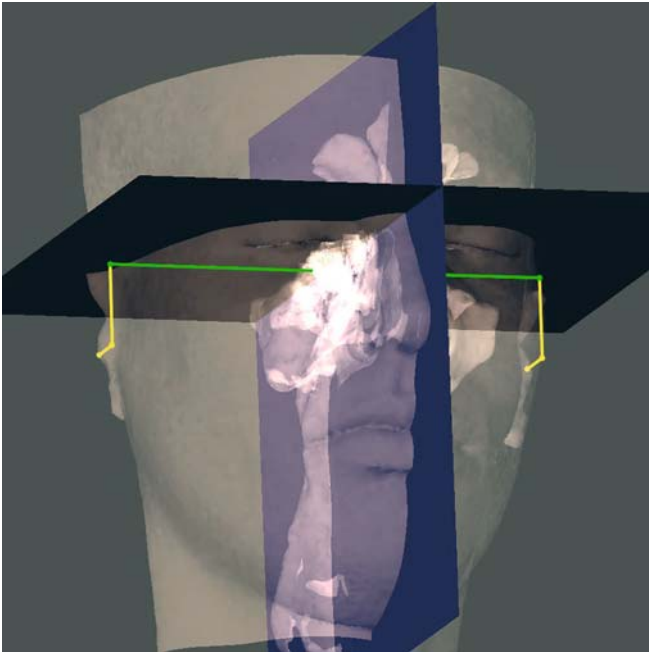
Width of the skull base, t_r-t_l (3-D CT, transparent soft tissues, patient K.C.)
